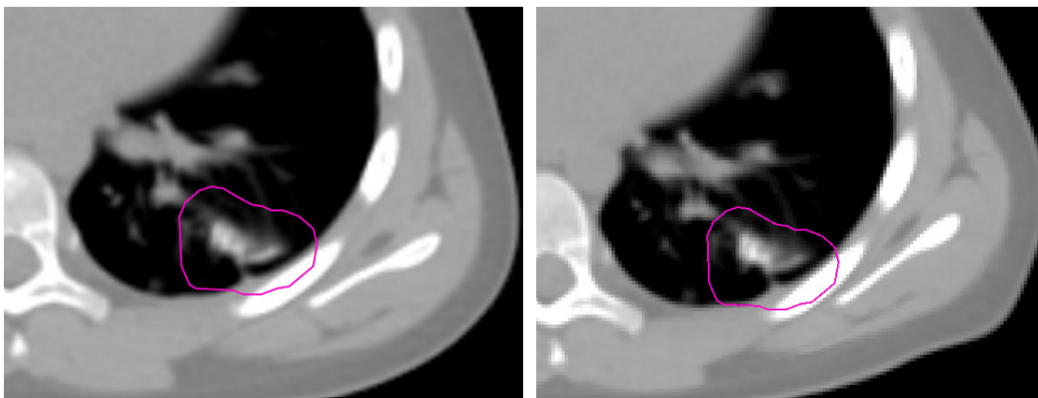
Position of the PTV of metastasis 1 of patient 1 on the averaged-CT (left) and on the registered-CT (right) for one fraction, in which it is possible to observe how in the registered-CT there is more rib volume within the PTV, resulting in an underdosage, as the rib absorbs more radiation than soft or lung tissue.
